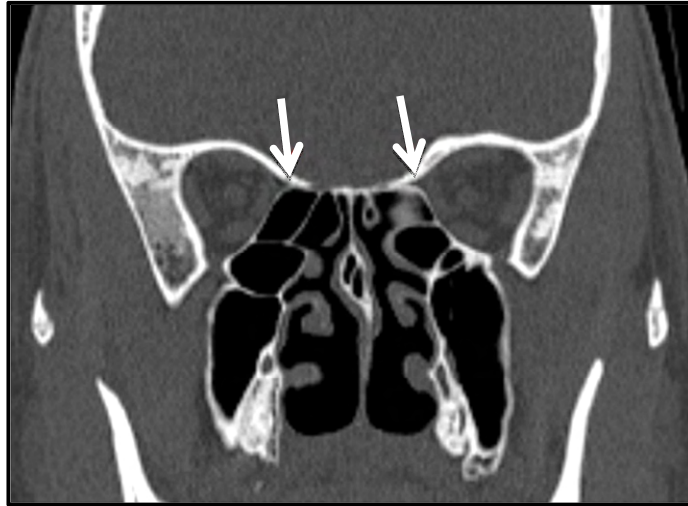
Coronal section of CT PNS showing presence of bilateral middle ethmoidal arteries in skull base position. (shown by arrows)
